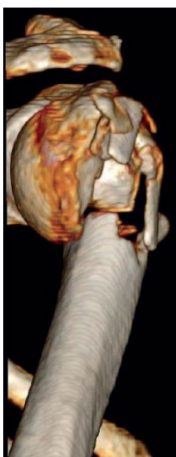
3D CT scan of the right shoulder joint, side view
